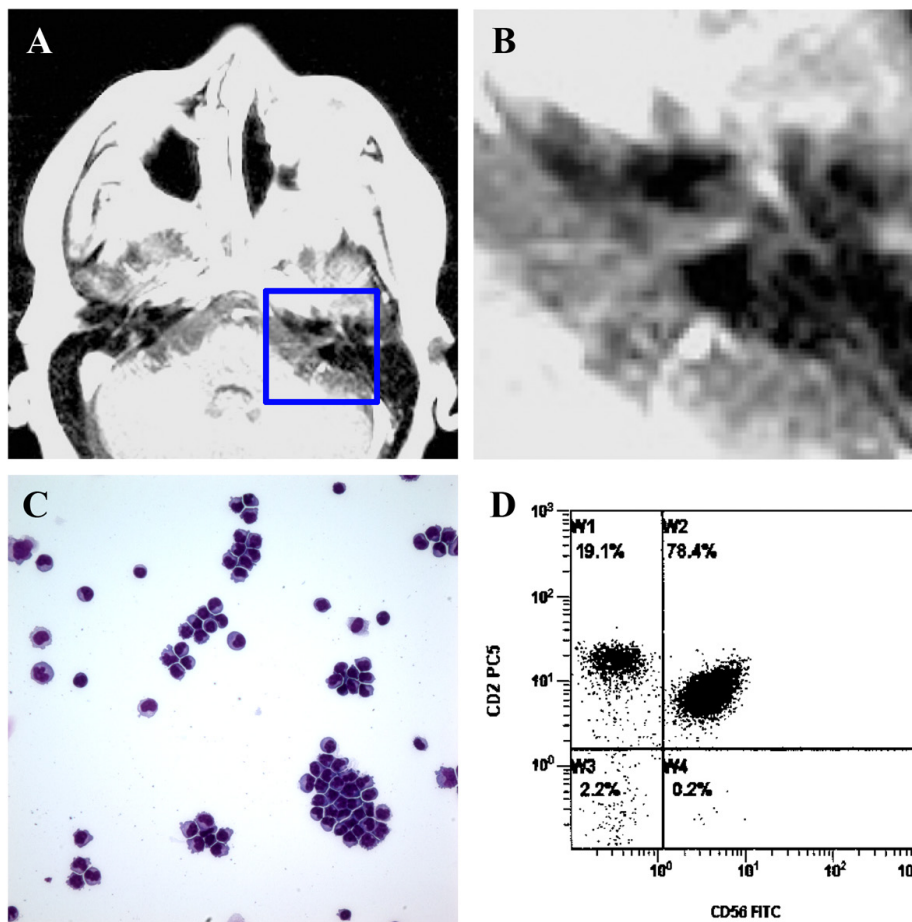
Dissemination of ENKTL, nasal type with leptomentigeal involvement. A and B: Repeat MRI of head revealed a faint enhancement in the course of left 7th nerve. B is the enlarged image of outlined area in A. C: Cytology of cerebrospinal fluid. D. Flow cytometry of CSF showed around 80% of CD45 positive cells positive for CD2 and CD56.
